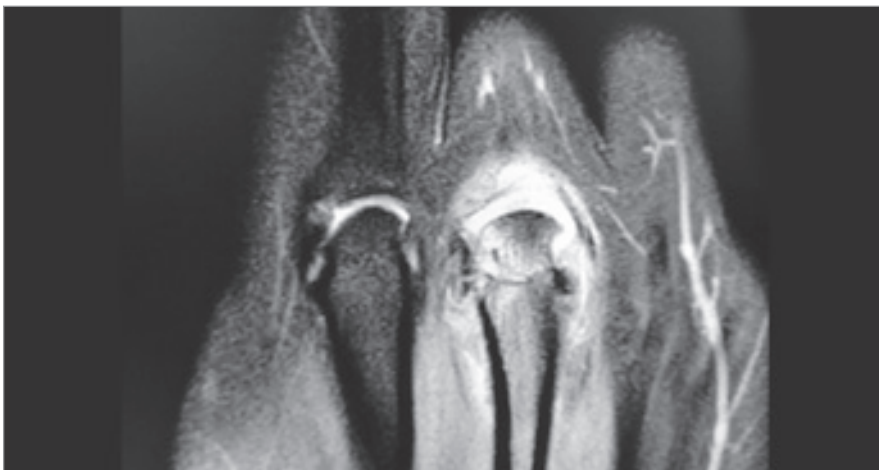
Preoperative MRI: signs of arthritis and cartilage erosion of the joint surfaces.
